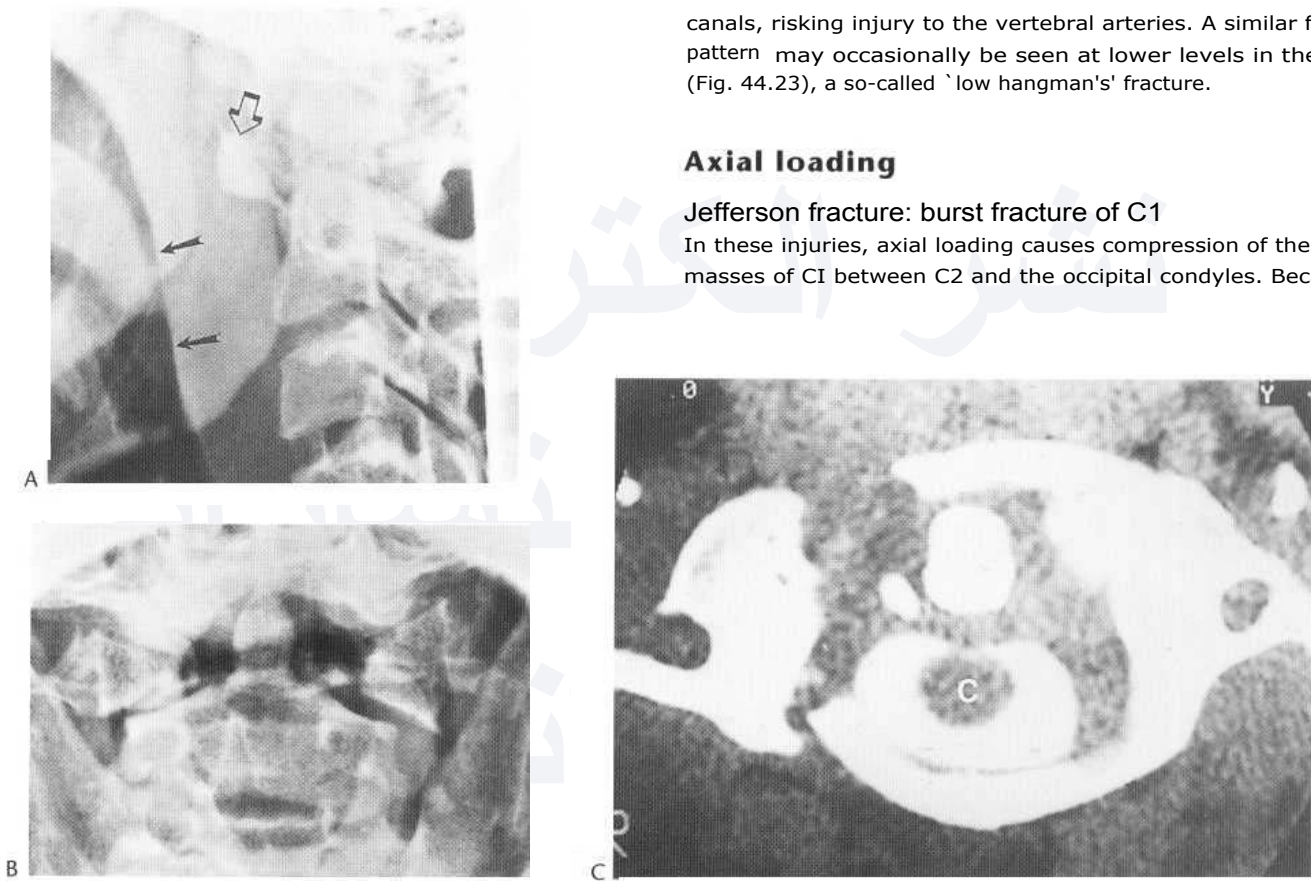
Jefferson burst fracture of C1. (A) The lateral view indicates anterior displacement of the anterior arch of C1 with respect to the odontoid process (open arrow). There is marked prevertebral soft-tissue swelling (closed arrows). (B) The AP view demonstrates lateral displacement of the lateral masses of C2. (C) Axial CT of Jefferson fracture of atlas. Contrast in subarachnoid space outlines cord.
